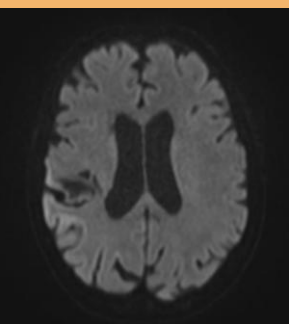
Cerebral MRI. Axial DWI. Right fronto-temporal-occipital subtle diffusion restriction
